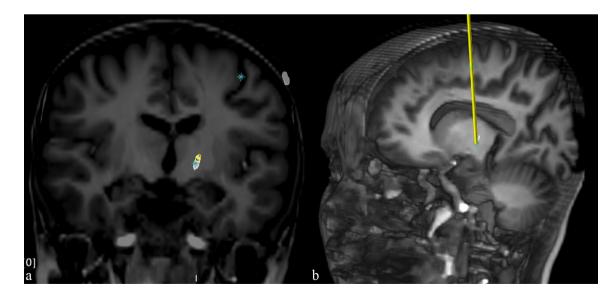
T1-weighted MRI coronal section (a) and 3D sagittal reconstruction (b) representing the trajectory plan of patient no. 3
